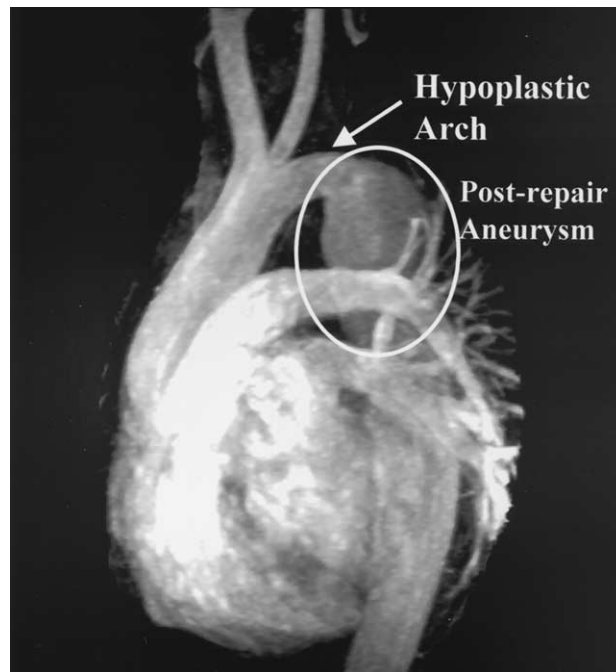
Magnetic resonance angiogram (T2-weighted). Arrow pointing to a 1.2-cm hypoplastic arch ( $> 16$  mm Hg gradient) and a poststenotic aortic aneurysm.
